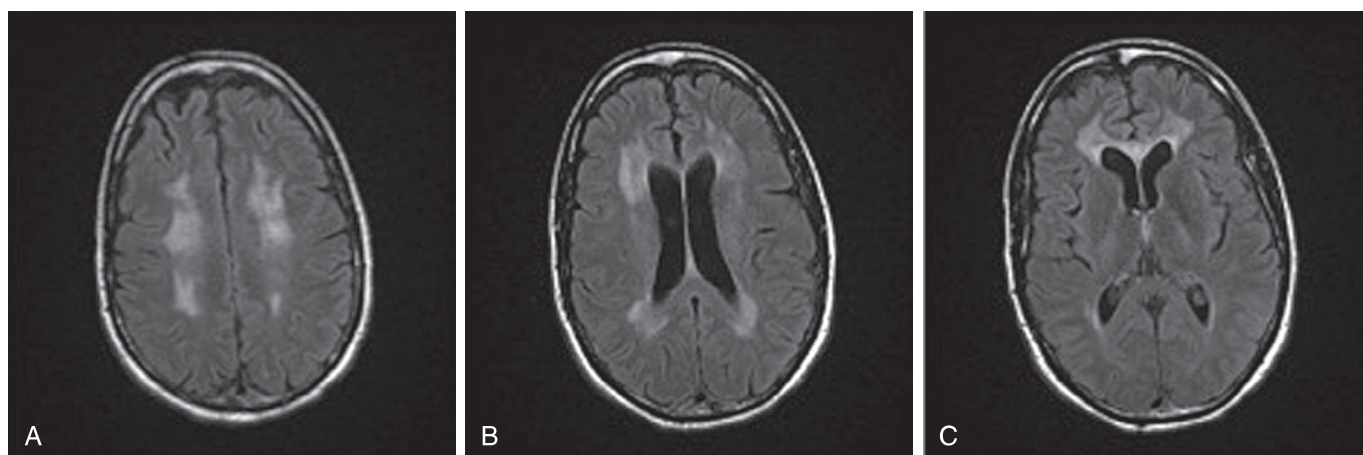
HIV encephalitis case example. A 42-year-old male, HIV positive for 15 years. Axial FLAIR images (A–C) demonstrate white matter lesions that are diffuse and symmetric with atrophy.
